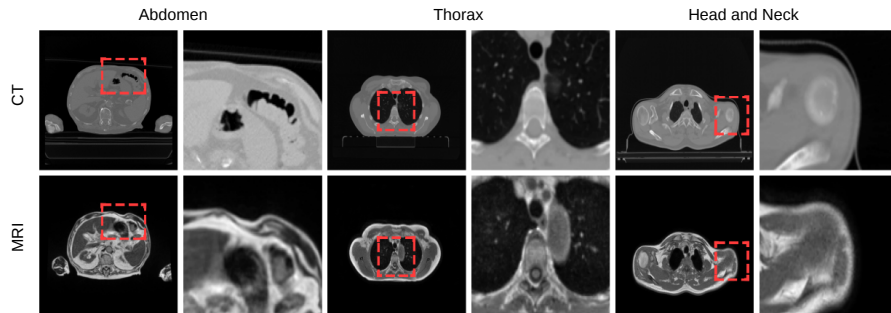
Residual misalignment after classical Elastix-based registration. Red bounding boxes highlight soft-tissue interfaces where CT and MR exhibit persistent misalignment across Abdomen, Thorax, and Head and Neck anatomies, with zoomed regions revealing structural inconsistencies that challenge cross-modality synthesis.
